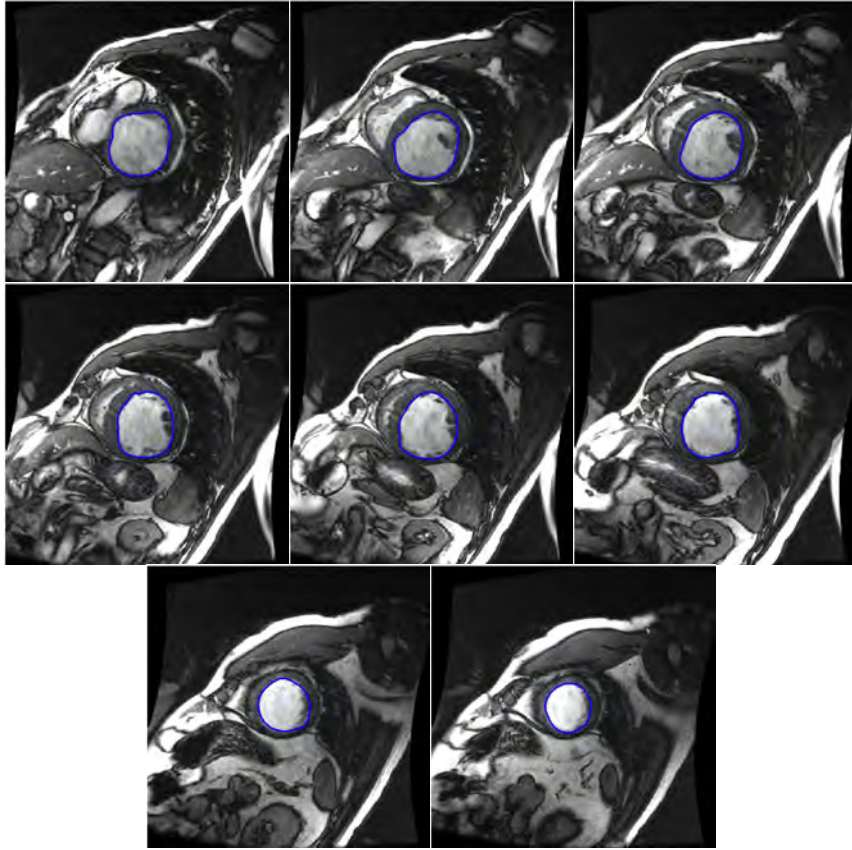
SAV MRI from SCD at the end diastolic cardiac phase for a patient with heart failure with segmentation performed on left ventricle endocardium (blue contours) from the base slice (upper left image) to apex slice (lower right image)
